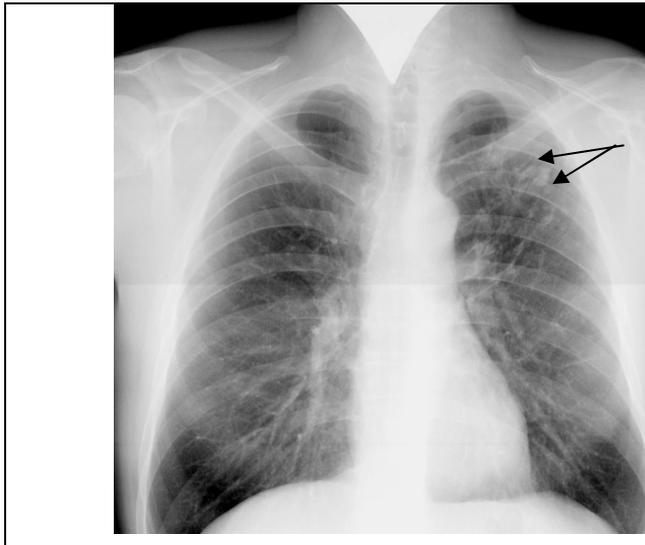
The frontal chest radiograph. In the first intercostal space on the left lung nodular shadowing with mottled character (arrows). Nodular tuberculosis of the left lung.
